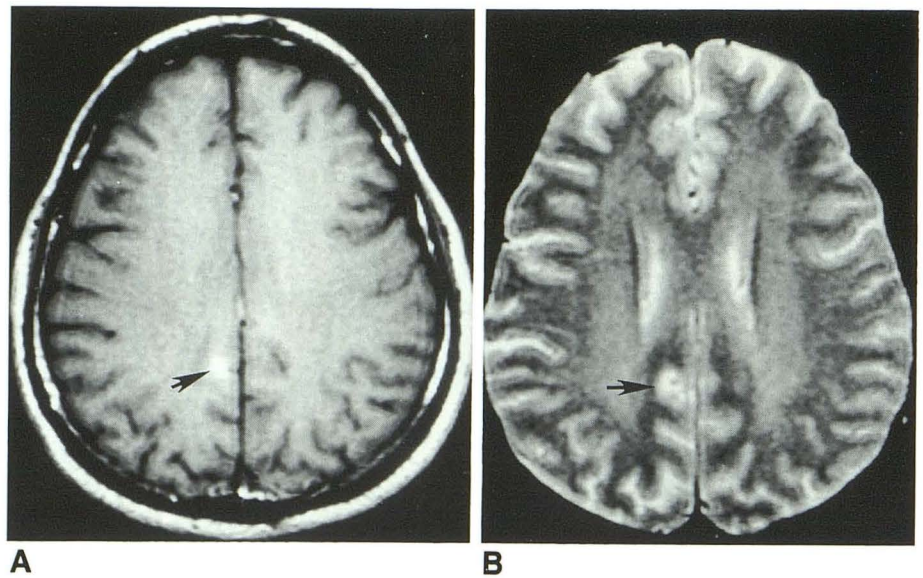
Patient with several mass lesions that responded to antitoxoplasma therapy. One lesion in the right occipital lobe seen on A, the postcontrast T1-weighted (600/20) image (arrow) was missed on B, the T2-weighted image (arrow). In retrospect, what was felt to be a prominent sulcus is in fact edema around the enhancing lesion. The precontrast T1-weighted axial image (not shown) was unremarkable in this area.
